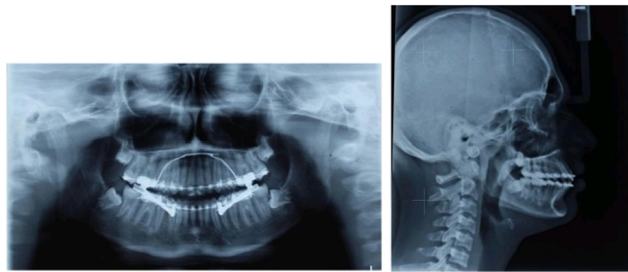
Radiographs after insertion of powerscope
